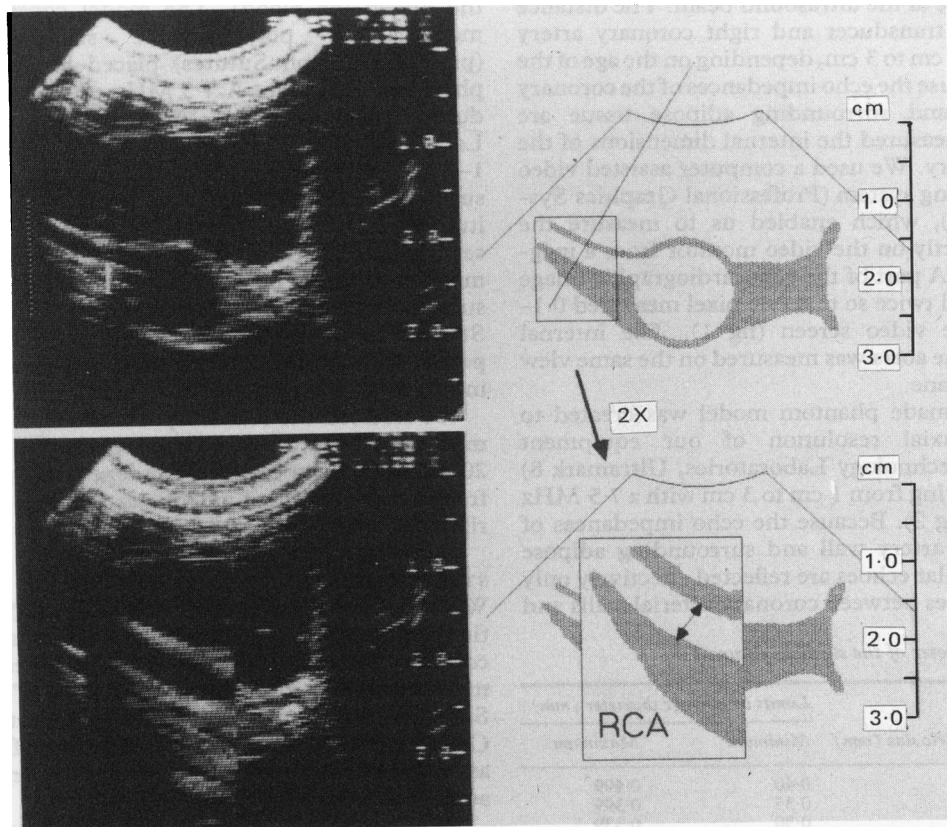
Echocardiographic method for measurement of right coronary artery (RCA) and aortic diameters. Measurement line is aligned with the axial beam. Right coronary artery is measured in a magnified image by PGS (Professional Graphic System, Symtec).
